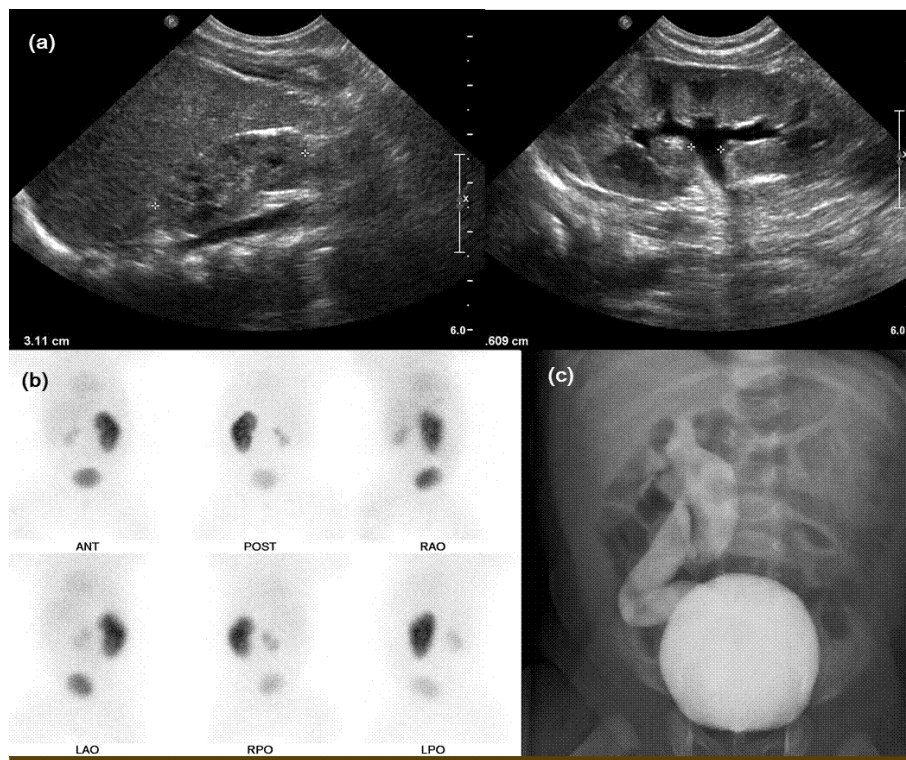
(a) Renal sonogram; right kidney (atrophic) and left kidney (hydronephrosis); (b) Dysplastic right kidney on dimercaptosuccinic acid renal scan; (c) grade V vesicoureteral reflux in right kidney on voiding cystourethrogram.
